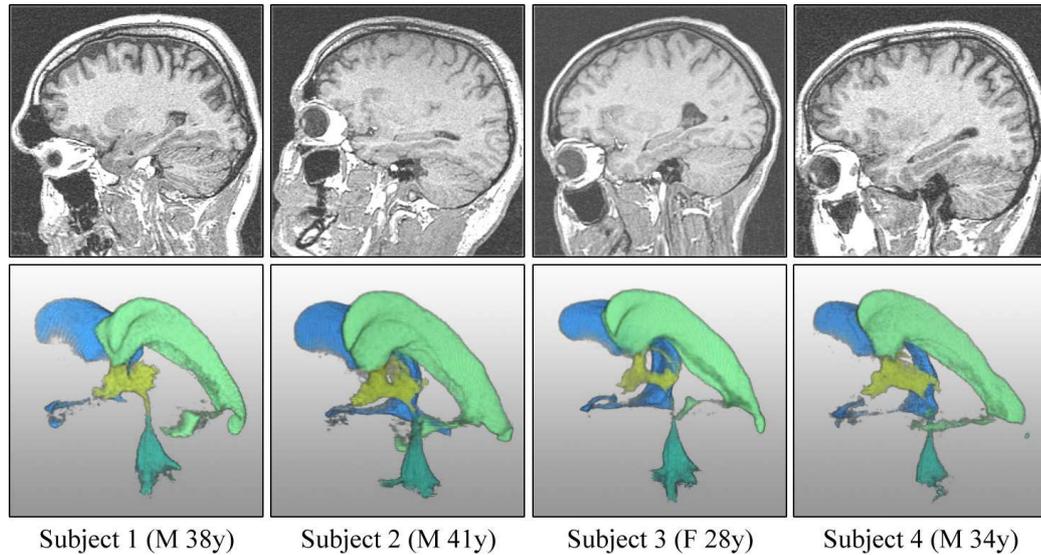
Material used for the evaluation of the proposed method. T1 weighted MR images from four volunteers (top); five acquisitions each. Using a software assistant based on the MeVisLab platform [MEVIS, 2004], the volumes of the cerebral ventricles were measured (bottom).
